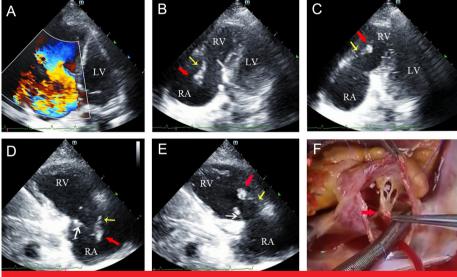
Echocardiography and gross pathology findings. (A) Oblique apical 4-chamber view revealing torrential tricuspid regurgitation; (B, C) Oblique apical 4-chamber view showing flailing of the anterior tricuspid valvular leaflet (yellow arrows) and the papillary muscle rupture (red arrows); (D, E) Parasternal right ventricular inflow tract view showing flailing of the anterior (yellow arrows) and posterior (white arrows) tricuspid valvular leaflets and the papillary muscle rupture (red arrows); (F) Intraoperative view demonstrating the anterior papillary muscle rupture (red arrow). LV, left ventricle; RA, right atrium; RV, right ventricle.
